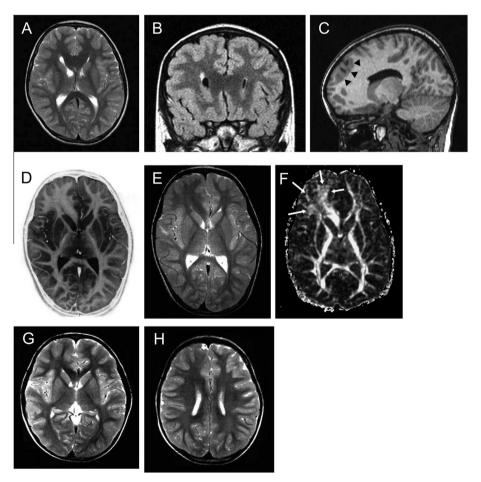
Magnetic resonance imaging of patients with unilateral frontal lobe megalencephaly (A, E, G, H: T2-weighted images, B: fluid-attenuation inversion recovery image, C: T1-weighted image, D: T1 inversion recovery image, F: fraction anisotropy map) (A–C: patient 1, D–F: patient 2, G and H: patient 3) Right frontal lobes appear larger than left frontal lobes in these patients. Blurring gray-white matter boundary (D), cortical thickening with polymicrogyric contour (arrowheads in C), and increased volume of ipsilateral frontal white matter and genu of the corpus callosum (A, D, E, G), are noted. In F, increased signal intensity of the callosal genu, and enlarged frontal white matter (arrows) are noted in the right hemisphere.
